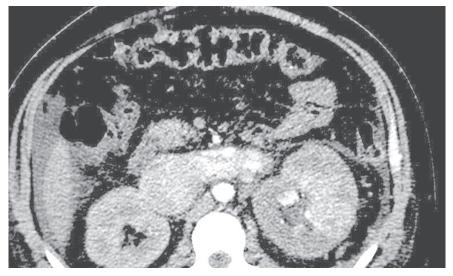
Contrast CT image showing left renal mass and tumour thrombus in IVC
